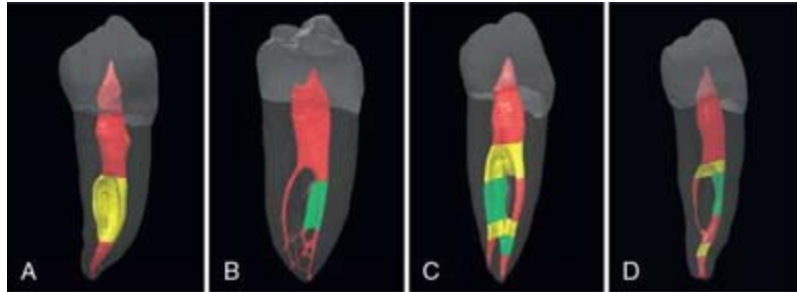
μ CT scans of mandibular premolars reflect a wide variation in canal morphology, moving from coronal to apical sections. The red color indicates a non-C-shaped canal space; green indicates a semilunar canal shape; and yellow indicates a continuous C-shaped configuration.
